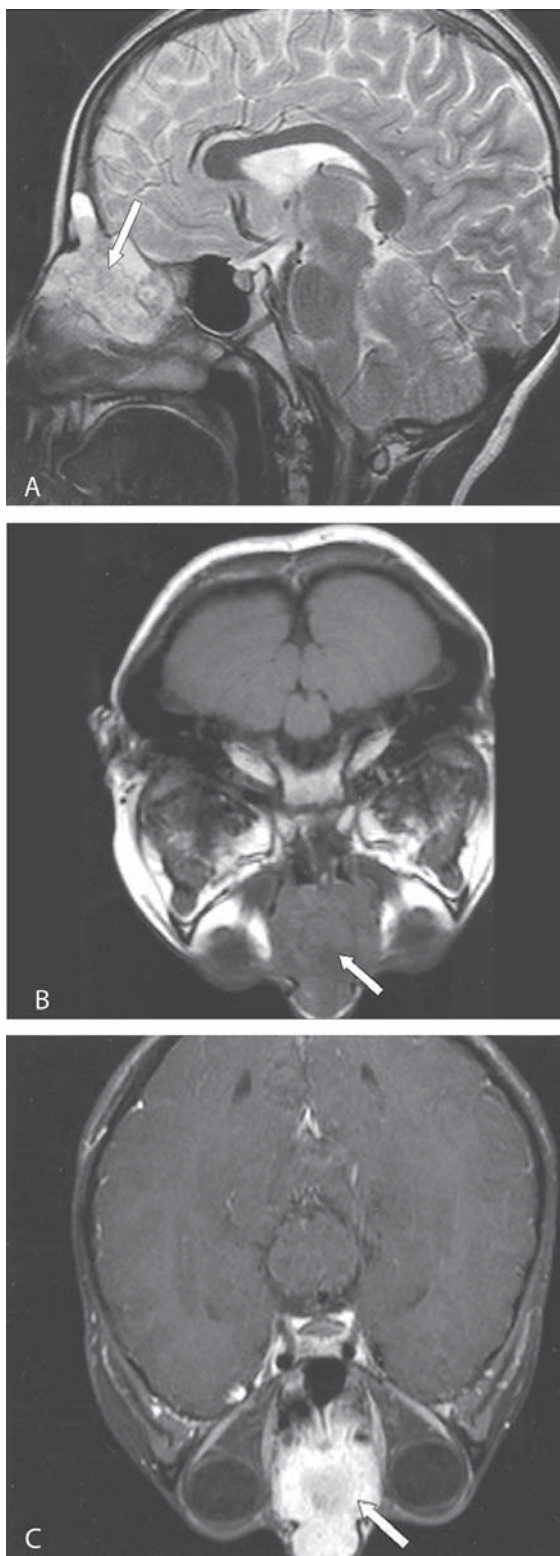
Sagittal T2-weighted (1a) and axial T1-weighted (1b) MR images show a solid mass originating from the nasal septum (arrows). Axial T1-weighted (1c) image after intravenous gadolinium shows bright, homogeneous enhancement throughout the lesion (arrow).
